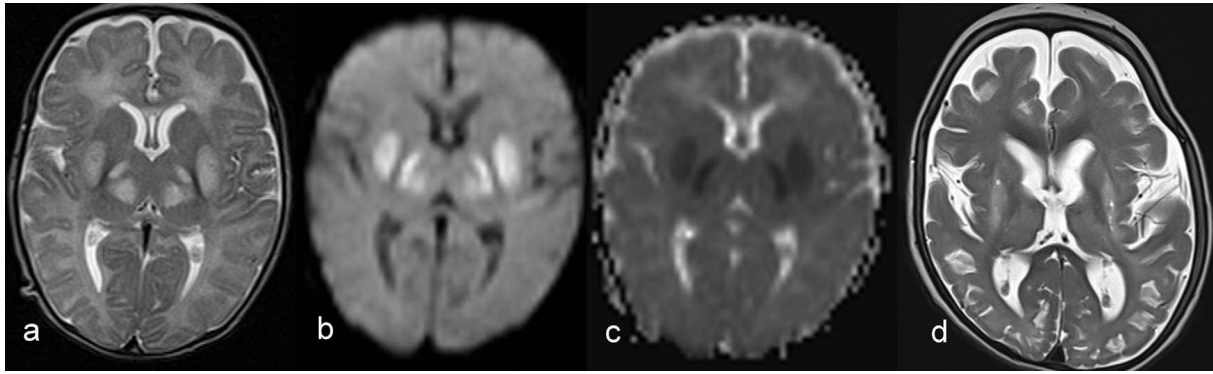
Axial T2-weighted MR image (a) shows symmetric hyperintense lesions in putamina and medial thalami. Diffusion-weighted image (b), and ADC map (c) findings are consistent with restricted diffusion. Following MR image (d) reveals diffuse cerebral atrophy and focal necrotic areas in basal ganglia.
